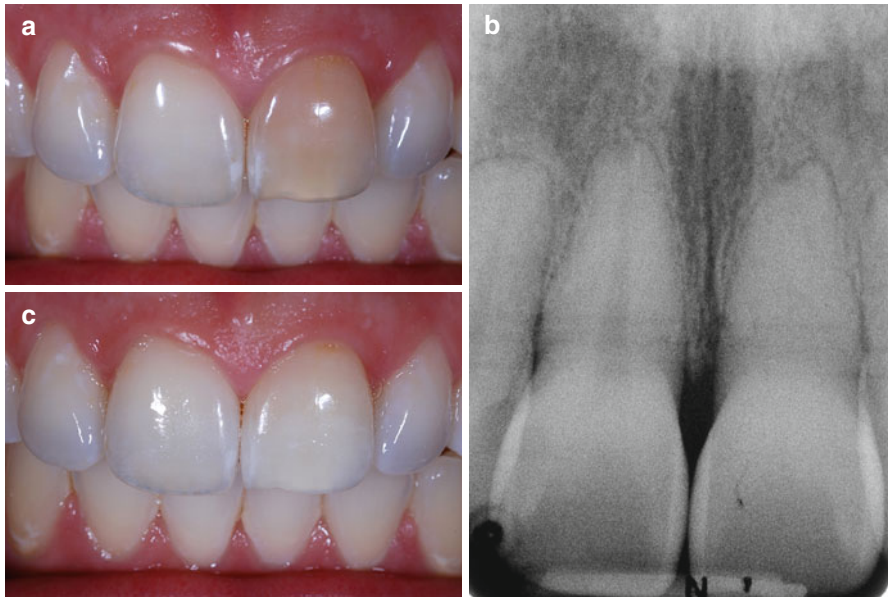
(a) Frontal view of maxillary incisors in a 26-year-old patient whose chief complaint was her discolored tooth #9 (FDI 2.1). Patient had had a traumatic injury to this tooth when she was 12 years old. No other signs or symptoms were associated with this tooth. Response to percussion was identical in all her maxillary anterior teeth. Although the response to cold was negative, the pulp responded to the electric pulp tester. (b) Periapical radiograph showing a calcified pulp space in tooth #9 (FDI 2.1). (c) Clinical aspect after 2 weeks of at-home whitening with 10% carbamide peroxide gel with potassium nitrate and sodium fluoride (Opalescence 10% PF, Ultradent Products, Inc.) in a custom-fitted tray. Patient decided to bleach for another period of 2 weeks, but she did not return for the recall appointment
